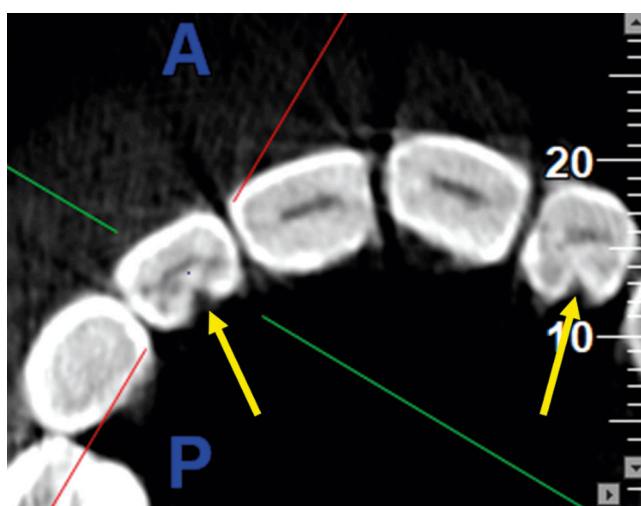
Cone beam computed tomography images showing a case with bilateral presence of palatogingival groove in axial section
